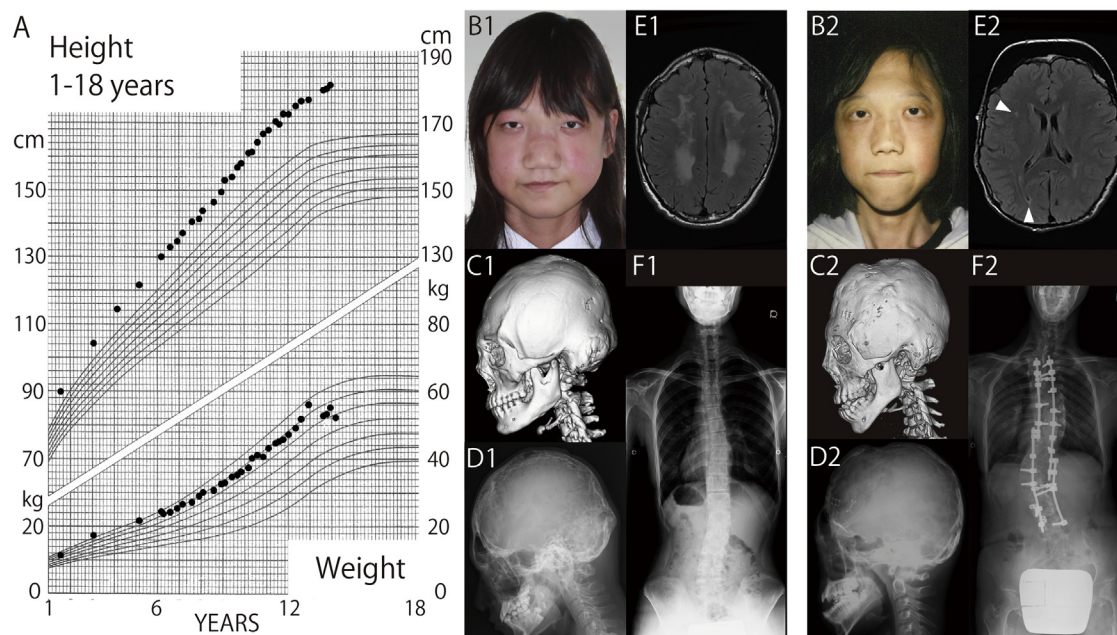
Clinical characteristics of the 2 patients. A, B1, C1, D1, E1, and F1, Images for Patient 1 and B2, C2, D2, E2, and F2, images for Patient 2 are shown. A, A growth chart shows accelerated linear growth for both weight and height. B1 and B2, Facial photographs. C1 and C2, Three-dimensional cranial computed tomography scans showing the protrusion of the posterior fossa. D1 and D2, Skull radiographs showing diffuse granular patterns. E1 and E2, FLAIR brain MRI results showing extensive periventricular white matter lesions (arrowheads in E2). F1 and F2, Total spine radiographs showing scoliosis.
